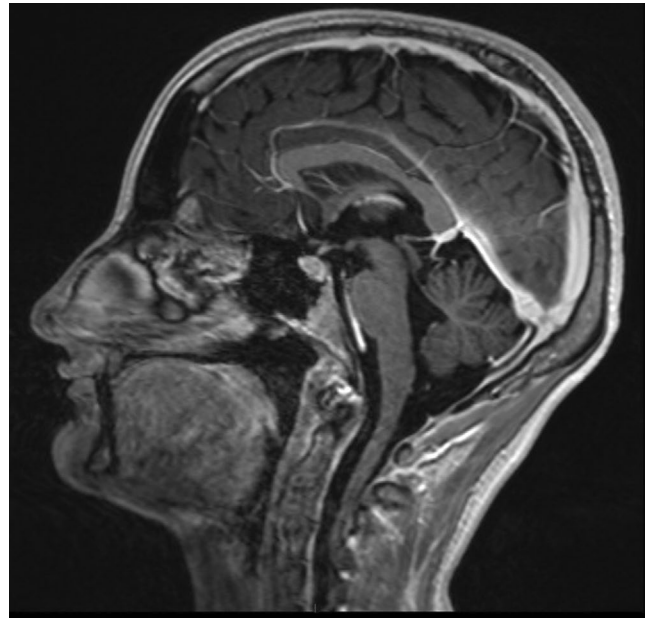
Preoperative Brain MRI
